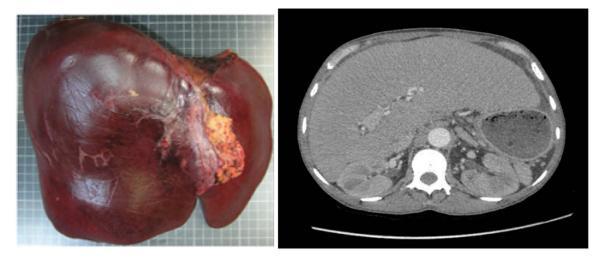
Congestive explanted liver due to massive liver vaso-occlusion leading to acute liver failure (left panel), with corresponding pre LT CT scan (right panel) showing a homogeneous hepatomegaly with no major changes suggestive of chronic liver injury apart from a limited atrophy of the right lobe. The liver explant weighed 2.1 kg, against 0.8 kg on average after liver transplantation for ALF from other origin, reflecting major sequestration.
